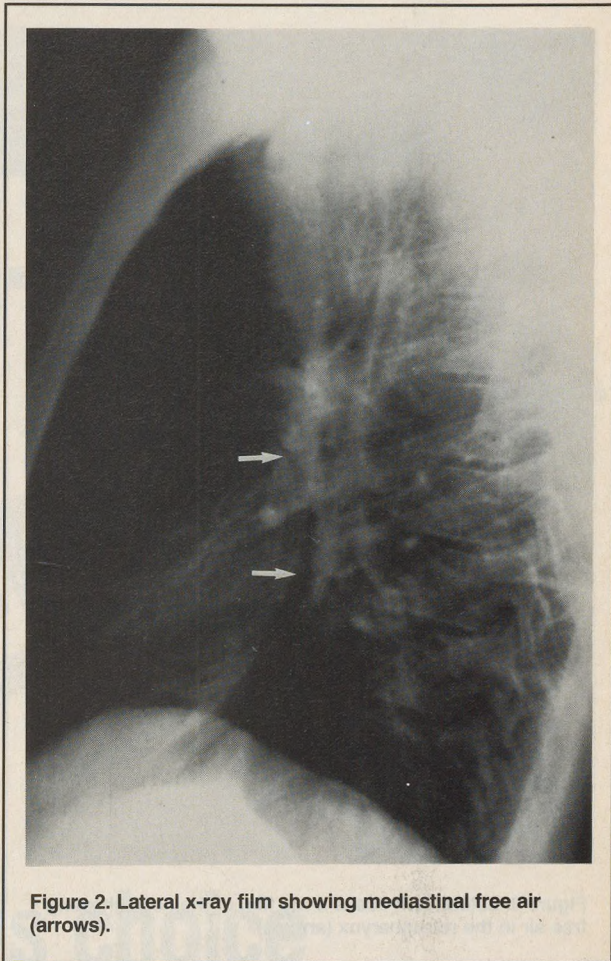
Lateral x-ray film showing mediastinal free air (arrows).
